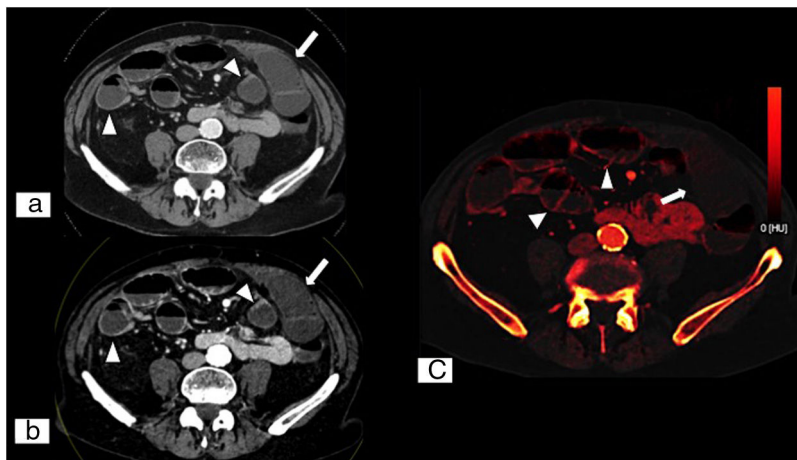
Acute mesenteric ischaemia secondary to adhesions. Abdominal and pelvic dual energy CT on an axial plane with intravenous contrast in a portal phase (A), low-kilovoltage (40 KeV) single energy image on an axial plane (B) and iodine map on an axial plane (C). These show lesser contrast uptake in the ischaemic loops (white arrows) compared to other loops with normal perfusion (tips of white arrows), with no obvious parietal thickening. Compared to conventional CT, low-kilovoltage single energy imaging enables tissues that exhibit iodine uptake to stand out more, which facilitates detection of areas of poorly perfused tissues. (Image courtesy of Marta Calvo Imirizaldu and Isabel Vivas Pérez, Radiology Department, Clínica Universidad de Navarra).
